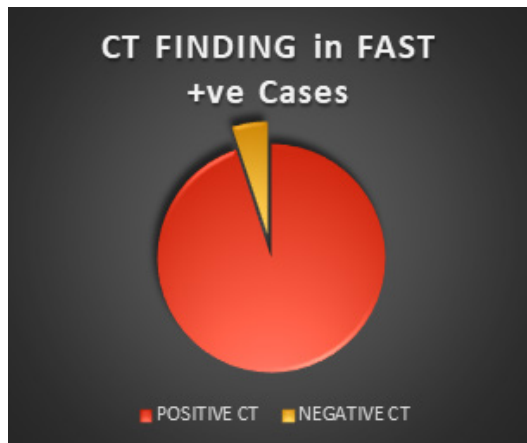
CT finding in fast + ve cases
